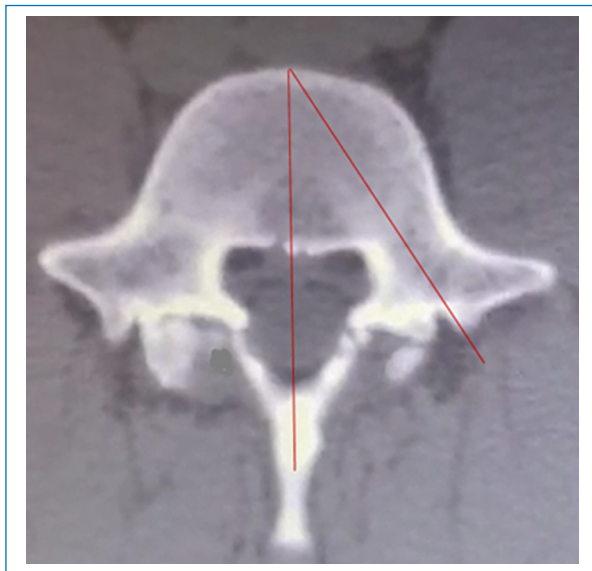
Simple computed tomography scan showing an axial cut of L5. The pedicle convergence angle is shown.
